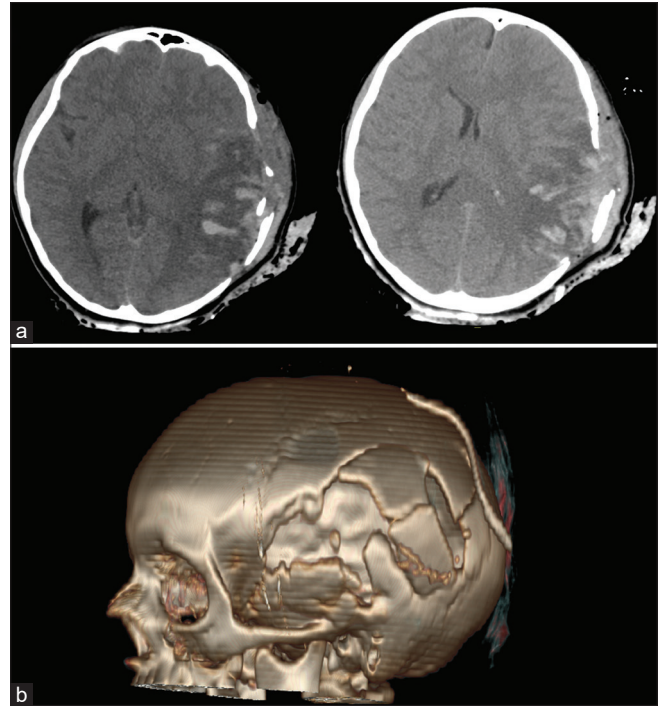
Preoperative brain computed tomography scan axial images showed multiple left fronto-temporo-parietal skull fractures and contusive-hemorrhagic lesions (a) and 3D reconstruction of the multiple skull fractures (b).
